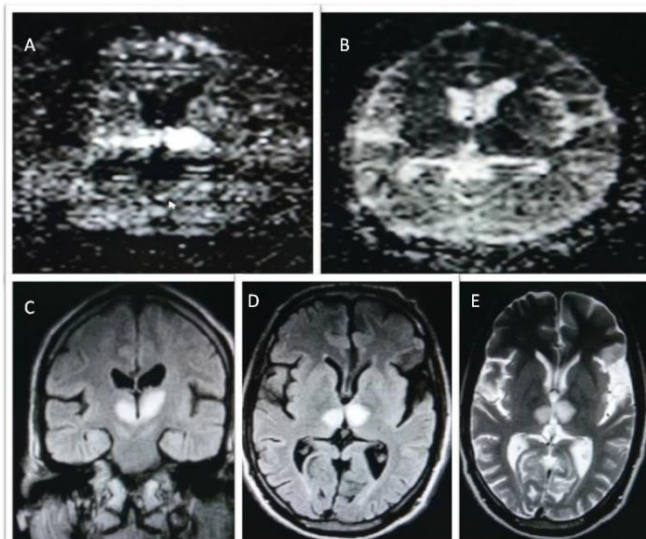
MRI axial section (A, B) shows a restriction on diffusion and low on ADC map, FLAIR (C, D) coronal, axial and T2 axial section (E) shows high signals on the bilateral paramedian area of the thalamus
